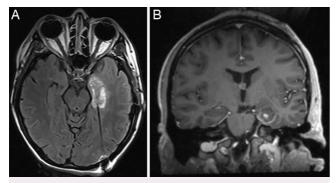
Posttreatment MRI sequences depicting laser ablation of mesial temporal seizure-onset zone. A: Axial fluid-attenuated inversion recovery sequence depicting laser probe trajectory and ablation volume.
